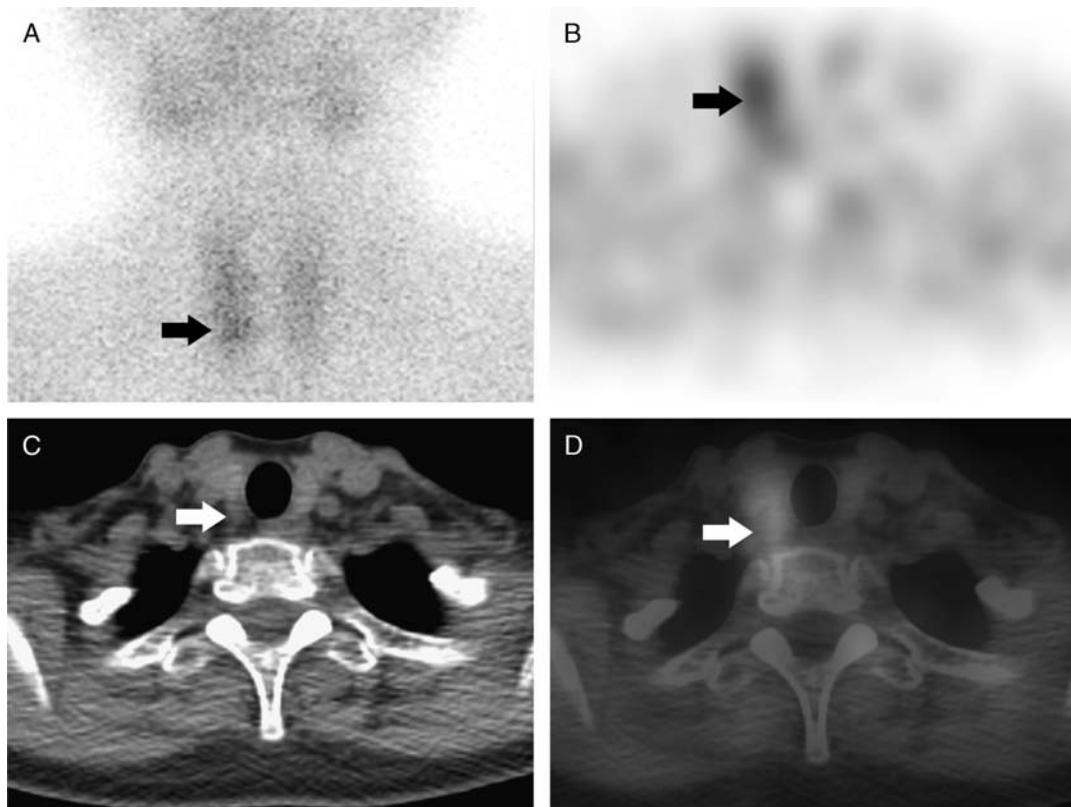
A 64-year-old woman with asymptomatic hyperparathyroidism (PTH, 185 pg/mL; serum calcium, 2.69 mmol/L) did not meet any surgical criterion initially. ^{99m}Tc-sestamibi study (A: early-phase planar image; B: axial CT; C: SPECT; D: fusion) showed a mildly increased focal uptake posterior to the right lower pole of the thyroid and a nodule in corresponding area on CT (arrows). Two years after the positive sestamibi study, surgical criterion was met because her serum calcium reached 2.85 mmol/L (>0.25 mmol/L above the upper limit of normal). Pathological examination postparathyroidectomy confirmed parathyroid adenoma.
